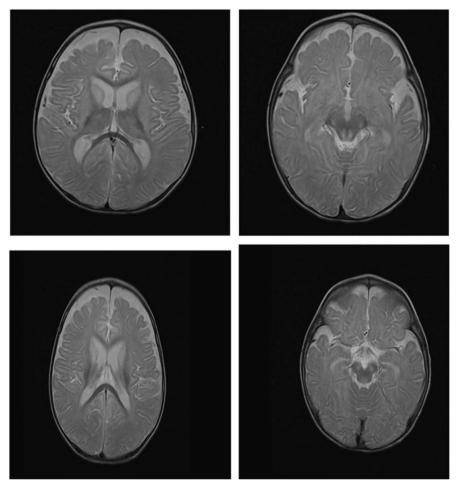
MRI of the patient's brain at the age of 11 months. Subtle bilateral diffuse subcortical and deep white matter T2 high-signal intensity was observed, showing evidence of diffusion restriction.
